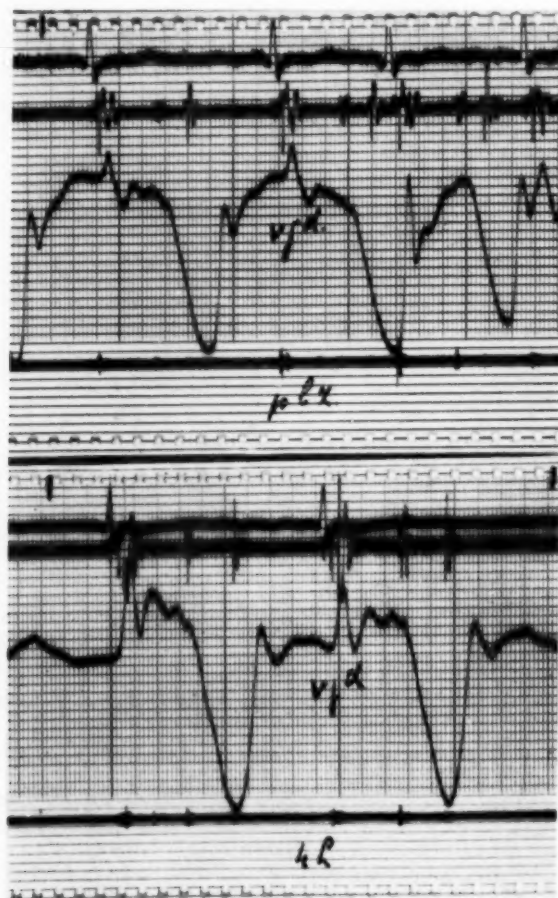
Venous tracing in constrictive pericarditis. The top picture shows in the intermediate frequency a third sound, recorded at the apex, and occurring in the descent of the *r* wave. It is thought to be a third sound from the left heart. The lower picture (from the same patient) shows a later appearing third sound, recorded in the fourth intercostal space parasternally and coinciding with the *y* depression, therefore presumably originating from the right heart.
